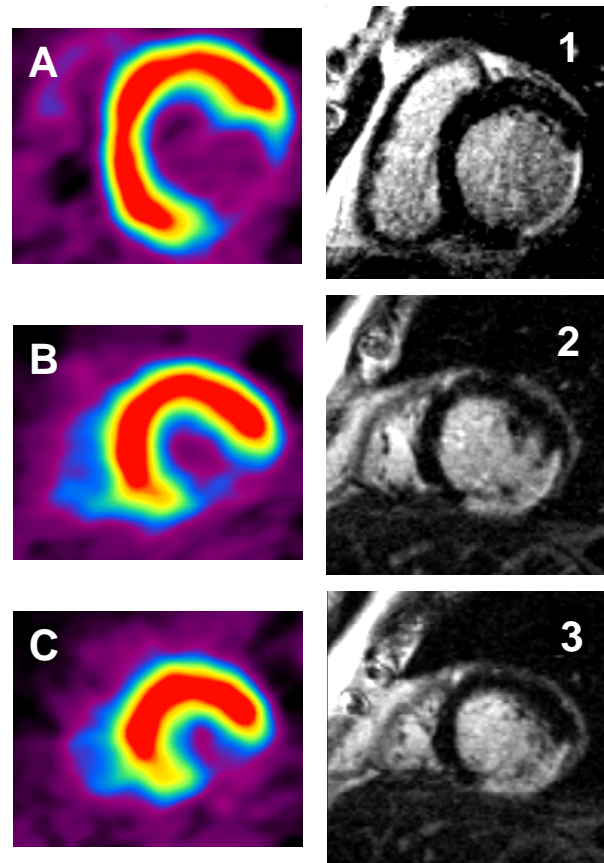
Example of a patient with a 36-month-old posterolateral myocardial infarction. The  $^{18}\text{F}$ -fluorodeoxyglucose-positron emission tomography images (left) reveal a defect in the posterolateral wall extending to the inferior wall at the basal (A), mid (B) and distal (C) ventricular level. Contrast-enhanced magnetic resonance imaging (right) shows transmural enhancement of a similar size in the same location (1,2,3). (Adapted from *J Am Coll Cardiol* 2003;41;p1347, fig 5). To view image in colour see original citation.
